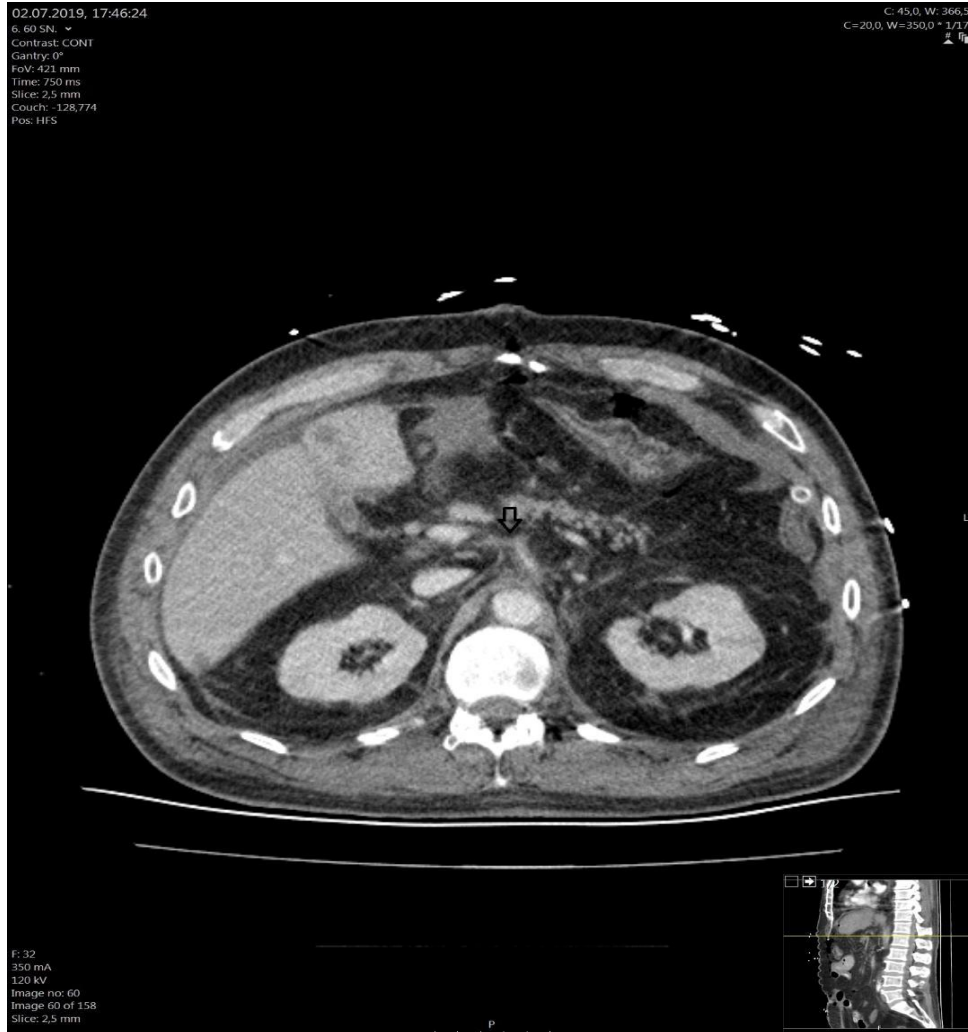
In contrast-enhanced axial multi-slice computed tomography, there is a significant narrowing of the celiac trunk orifice and the opening cannot be clearly defined. Significant narrowing of the celiac trunk lumen and hypodense thrombus formation along the wall
